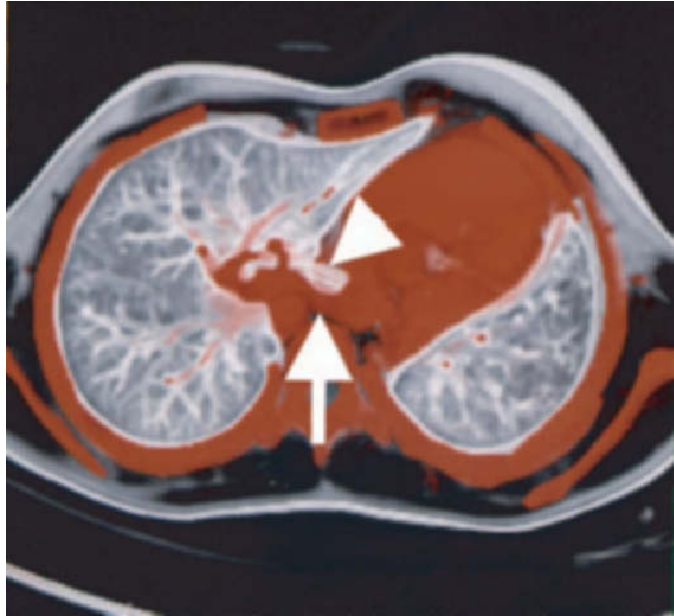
Pulmonary sling. A superior perspective VR MDCT with CTA demonstrates the left pulmonary artery (arrow) extending behind the bowed trachea (arrowhead).
